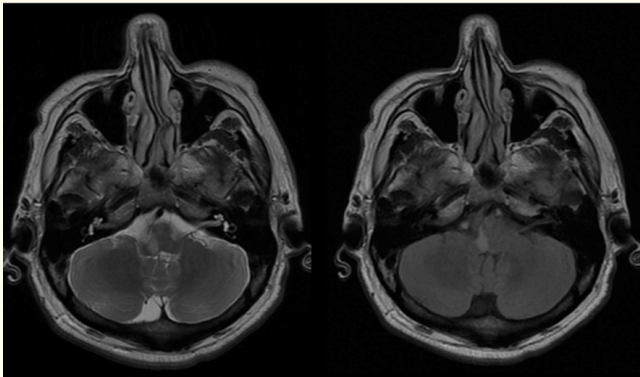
MRI of the skull in an axial plane at the level of the posterior fossa showing a hyperintense oval image in T2 sequence and in FLAIR located in the lateral aspect of the medulla.
